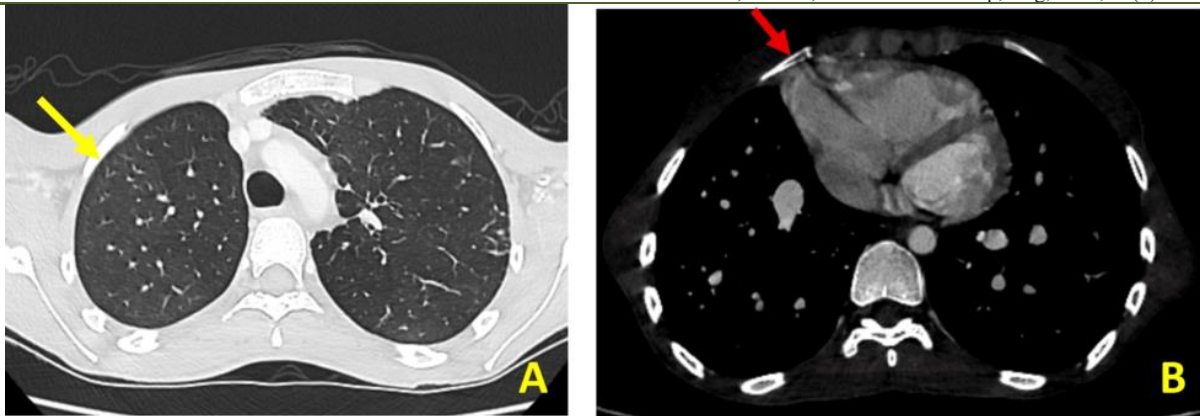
Axial contrast-enhanced CT images in parenchymal (A) an mediastinal (B) window showing right lung hypoplasia (yellow arrow) and mediastinal shift with dextroposition of the heart (red arrow)
